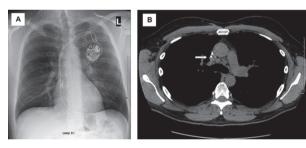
Initial chest imaging in 47-year old male (subject 17) subsequently diagnosed with cardiac sarcoidosis. A. Chest x-ray showing no significant abnormalities. B. Computed tomography of the chest showing mediastinal lymphadenopathy (white arrow)
